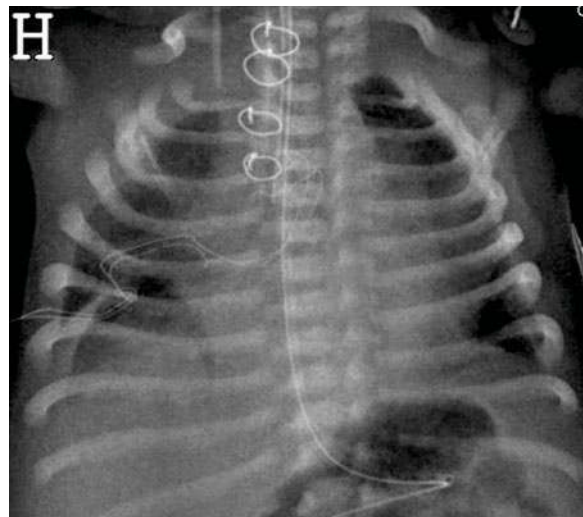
A 10-day-old boy. Postoperative chest radiograph exposed with the patient in lordosis. The anterior rib ends curve cranially instead of caudally. The heart contours are different from a normal projection, with the apex lifted. Note the clavicles projected high above the first ribs
